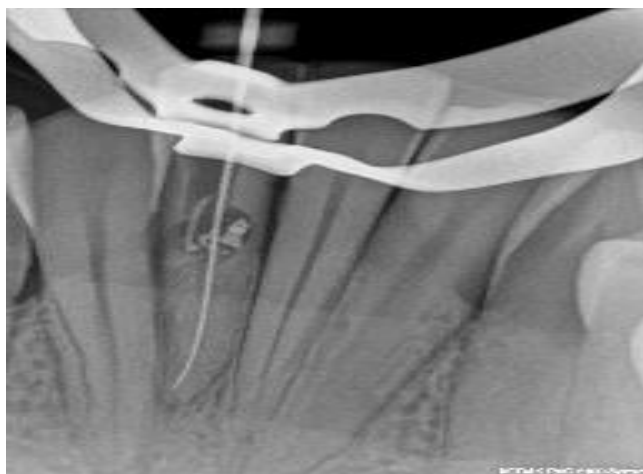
Conductometry radiograph showing the working length.
